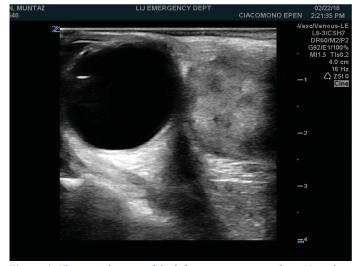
Ultrasound image of the left eye in transverse plane. Note the hyperechoic, heterogenous structure adjacent to the orbit.
